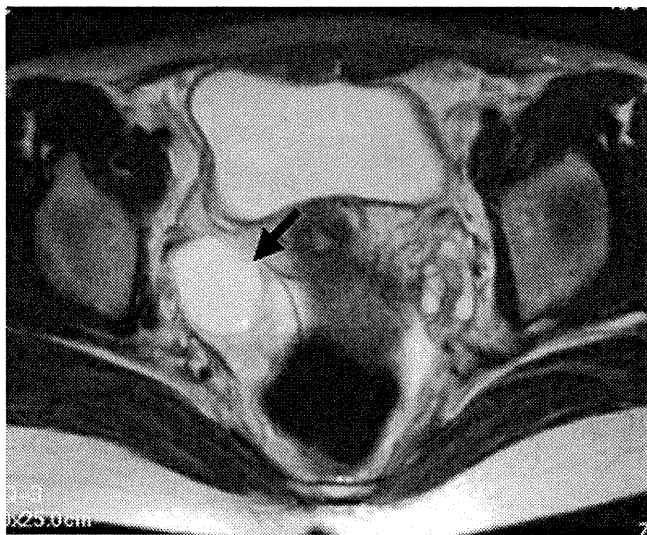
T2-weighted axial magnetic resonance images of the pelvic region showing ovarian cyst (arrow).
